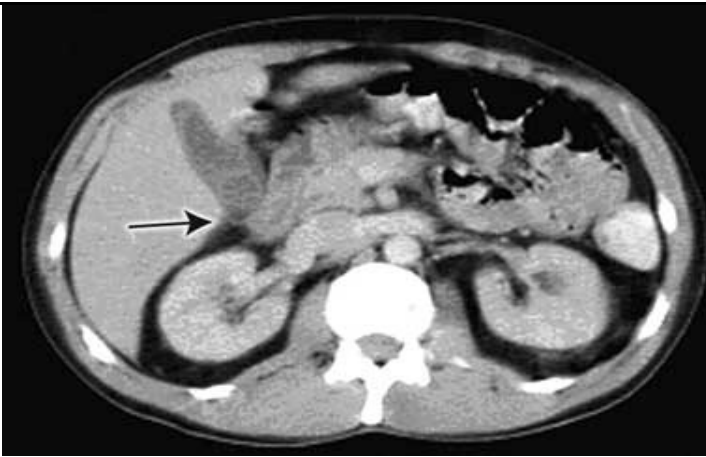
Computed tomography on admission showed pericholecystic inflammation, suggesting acute cholecystitis, and a possible gallstone.
